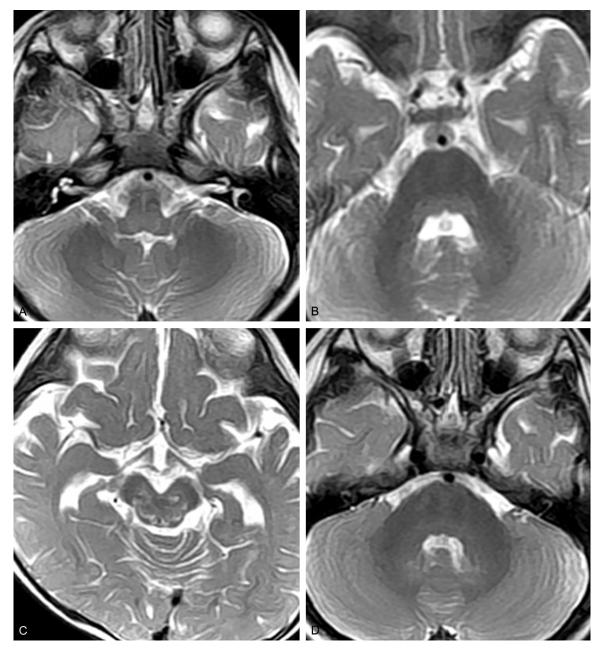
Brain MRI of Case 6. Before treatment: (A) T2-weighted image showing bilateral hyperintense signals in the posterior medulla oblongata, (B) T2-weighted image showing mildly hyperintense signals in the posterior pons, (C) T2-weighted image showing patchy hyperintense signals in the red nucleus, substantia nigra, oculomotor region, and trochlear nerve nucleus. (D) Repeat MRI after 4 weeks showing disappearance of the pontine lesion.
